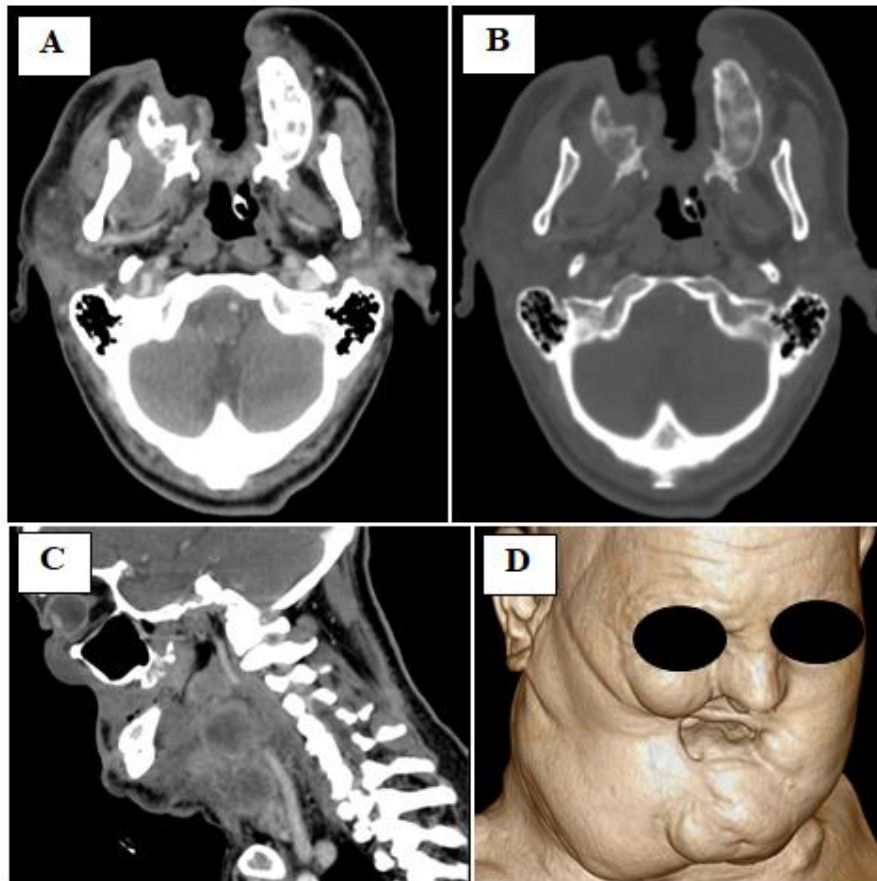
Cervico-facial CT in August 2023: Axial section in parenchymal (A) and bony (B) window, showing the ulcerative-budding upper labial process, heterogeneously enhanced after injection of the PDC, with rupture of the bony cortex next to the 13th dental root. (C) Sagittal section with injection of contrast product, showing the upper labial process with magma of right jugulocarotid lymphadenopathy, encompassing the vascular axis which remains permeable. (D) 3D VRT reconstruction
